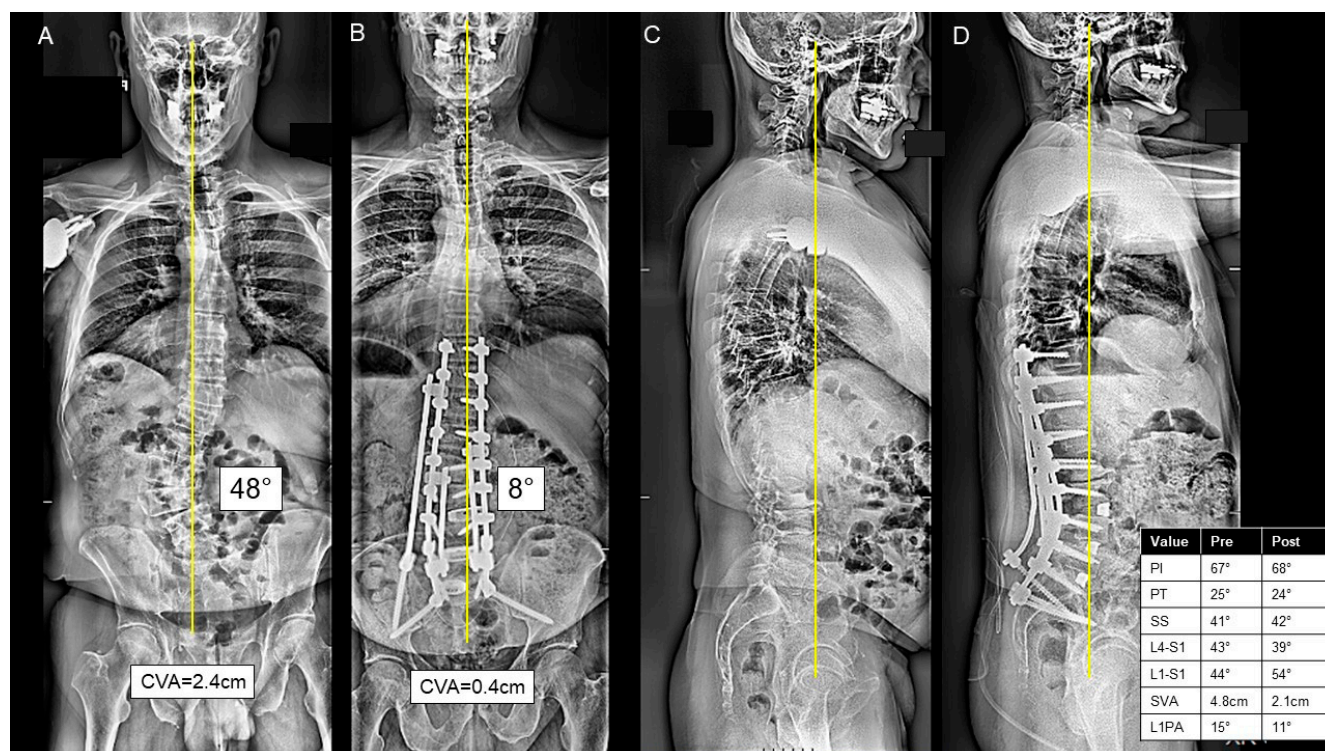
(A–D) A case presentation of a 67-year-old male with severe L2 and L3 right-sided radiculopathy, left-sided L4 radiculopathy, severe mechanical back pain, and inability to walk for more than 5–10 min, who was found to have a significant degenerative scoliosis in the thoracolumbar and lumbar spine on the postero-anterior (PA) (A) and lateral X-rays (C). The patient underwent a posterior-only approach consisting of T10-ilium posterior spinal instrumentation; T10-S1 inferior facetectomies; L1-S1 posterior column osteotomies; a total of 3 transforaminal lumbar interbody fusions at L3/L4, L4/L5, L5/S1; decompressive foraminotomies at L5/S1, L4/L5, L3/L4 and L2/L3; and a cobalt kickstand rod from T11/12-S1 with compression and distraction forces to correct the scoliosis, as seen on the postoperative PA (B) and lateral X-rays (D). The patient was discharged home at postoperative day 5.
